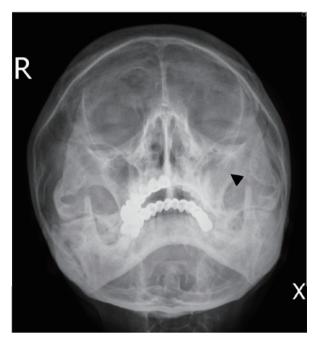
Radiography of paranasal sinuses shows increased haziness at left maxillary sinus (arrow head), compatible with sinusitis.
